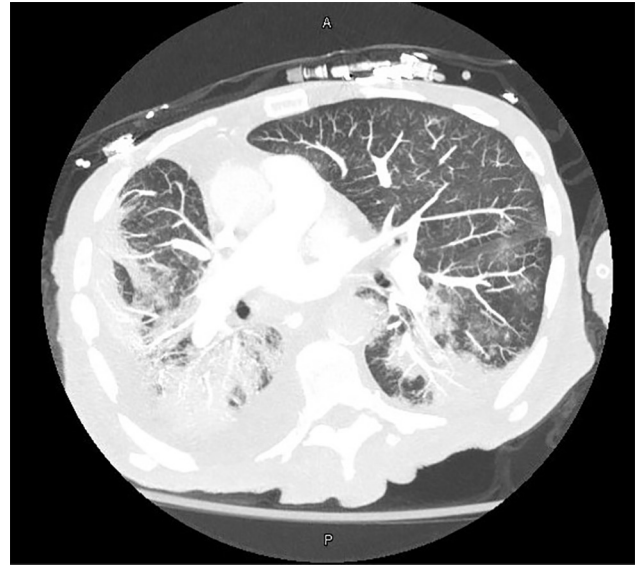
Computed tomography image of the chest showing bilateral dense consolidations and right-sided pleural effusion in 77-year-old man with severe acute respiratory syndrome coronavirus 2 who was later found to be co-infected with *Bordetella hinzii*. A, anterior; P, posterior
